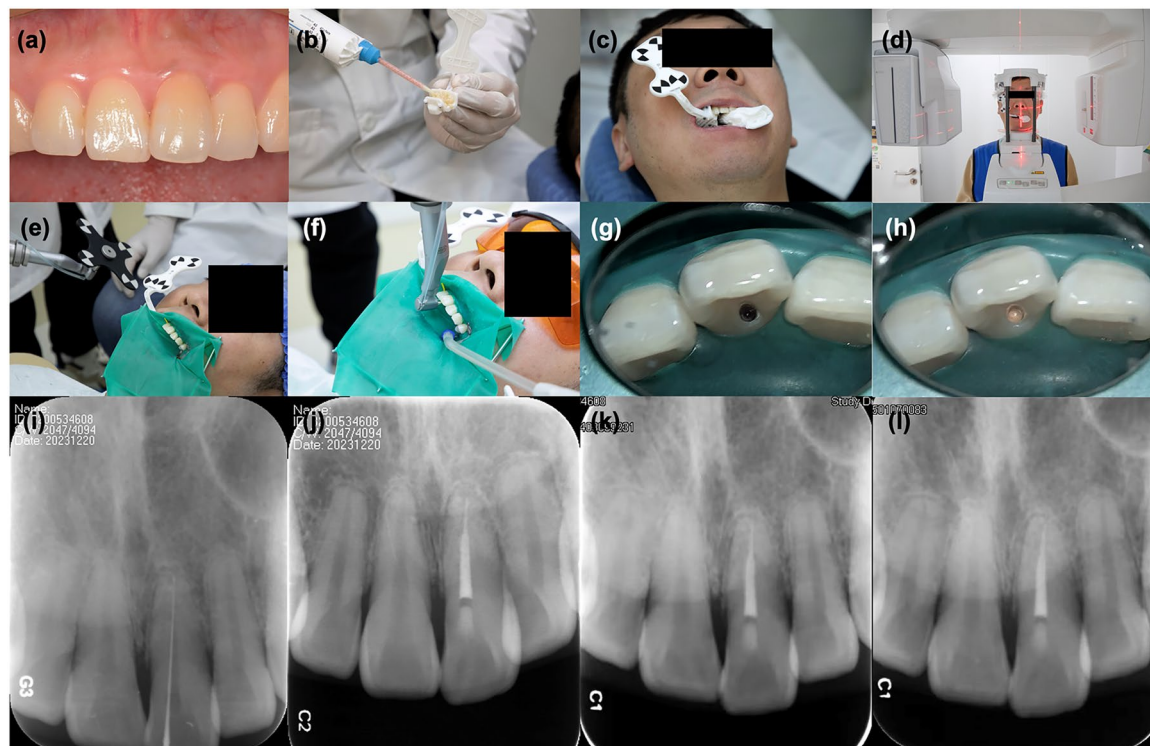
Clinical procedure. (a) Clinical view of tooth #9 (b) Self-cured acrylic resin was injected to the marker by the operator. (c) The marker was fixated on the contralateral teeth in upper dentition. (d) Patient underwent CBCT scan with the marker. (e) Registration of the handpiece with the marker. (f) Access cavity preparation was conducted automatically by the robotic arm. (g) Access cavity has been built and root canal could be located. (h) After obturation (i) Periapical radiograph with initial apical file showed that the canal had been negotiated to the full working length. (j) Postoperative periapical radiograph. (k) Radiograph of 3-month follow-up. (l) Radiograph of 12-month follow-up.
